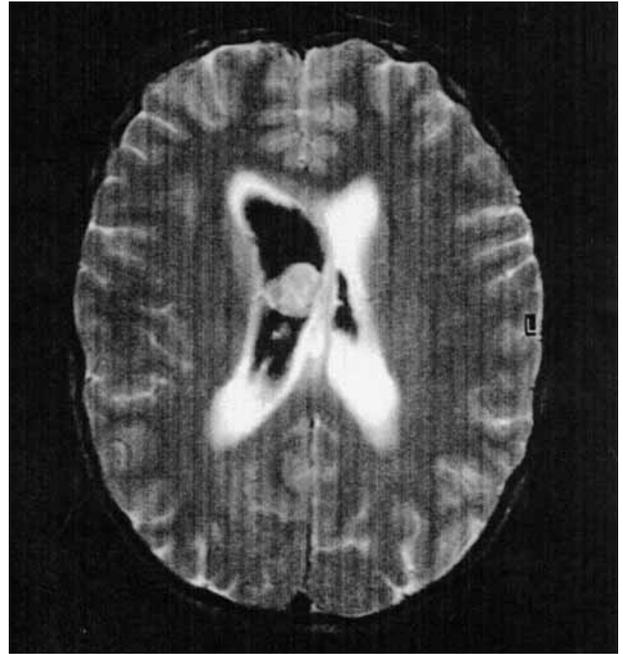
(two days after admission) Axial T2-weighted MRI of the brain showed blood in the lateral ventricles, more prominent on the right side and a small nodular lesion in relation with the corpus callosum. The mass was slightly inhomogeneous and hyperintense. There was no enhancement after injection with Gadolinium.
